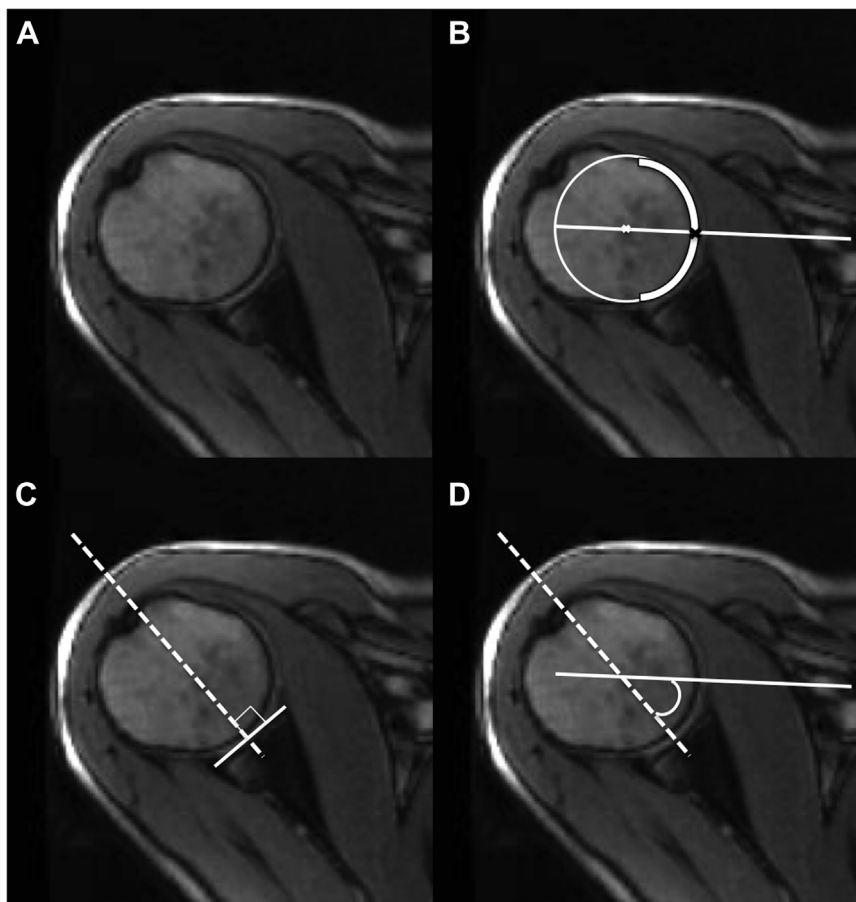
Determination of rotational angle on images captured using cine-magnetic resonance imaging. (A) Showed a raw figure. (B) The axis of the humeral head was defined as the line connecting the center of the humeral head and the midpoint of the humeral head surface. (C) centerline of the glenoid was defined as the line perpendicular to the surface of the glenoid fossa at its midpoint. (D) The angle of rotation was defined as the angle between the two lines, with the zero point at the intersection of the axis of the humeral head and the centerline of the glenoid.
